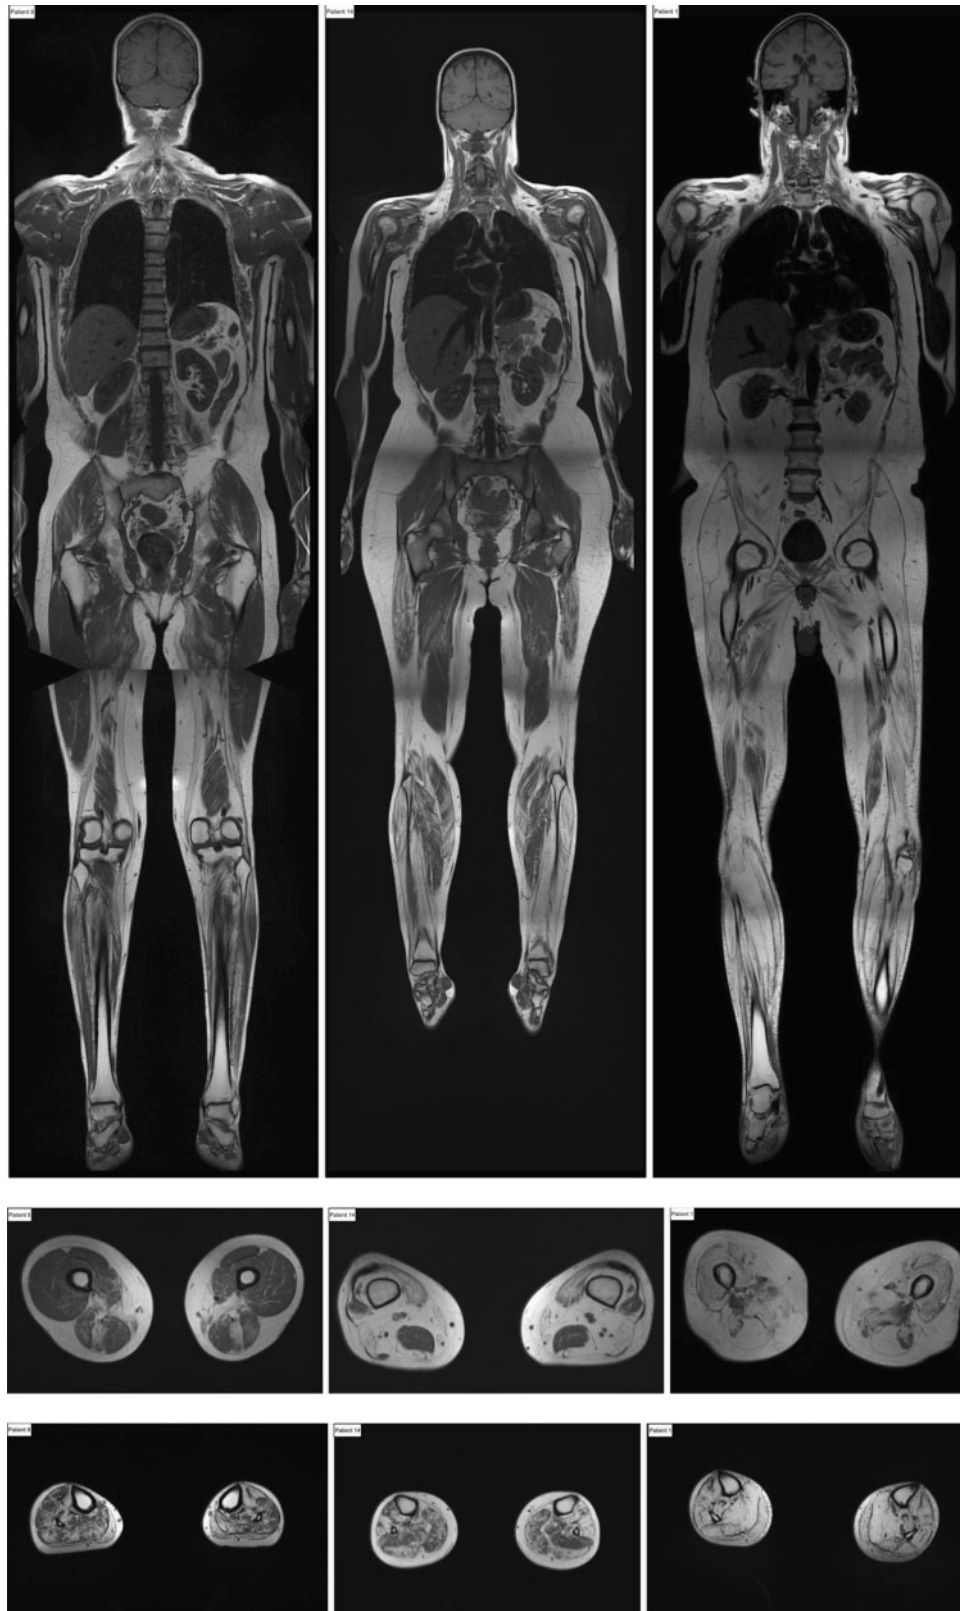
Whole body MRI scans (T1-weighted images) and transverse sections of upper and lower-limb muscles. Patient 8: (left) symmetric atrophy and degeneration of deltoideus muscles, while biceps brachii, supra- and infraspinatus muscles are relatively spared. Note the marked involvement of trunk muscles, proximal and distal lower-limb muscles with predominance of fatty degeneration in tibialis anterior muscles. Patient 14: (middle) marked atrophy and fatty degeneration of proximal and distal leg muscles, predominantly in the dorsal leg compartment, while in the upper extremities only deltoideus muscles are mildly affected. Patient 1: (right) marked atrophy and fatty degeneration of proximal and distal muscles, only the biceps brachii muscle is relatively spared.
